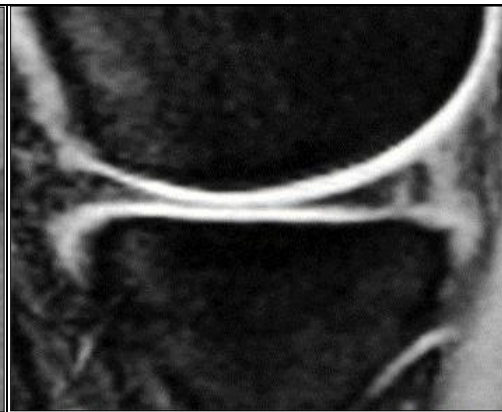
MRI T₂ weighted sagittal images showing longitudinal tear of posterior horn of meniscus
